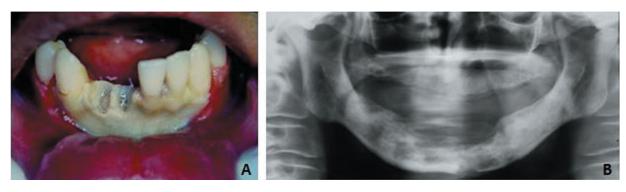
Clinical aspect of bone exposure and necrosis in a patient with osteoradionecrosis after radiotherapy treatment (photograph kindly provided by Dr. Marcos Martins Curi). B: Panoramic radiograph showing irregular osteolytic areas in the mandible of a patient with osteoradionecrosis
